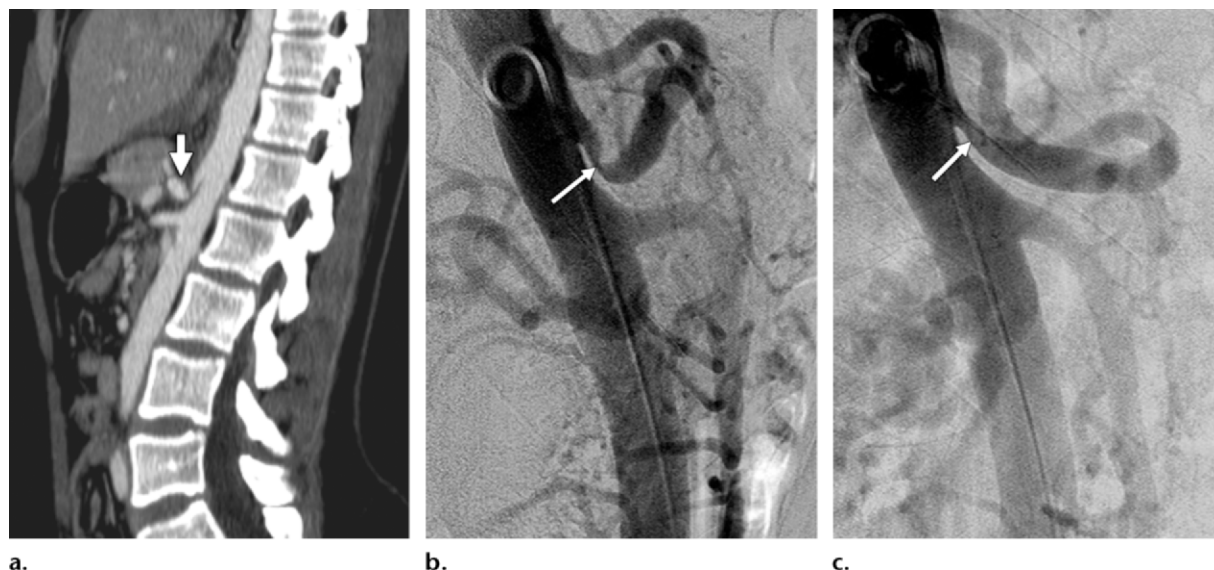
Median arcuate ligament syndrome in a 45-year-old woman with postprandial abdominal pain, intermittent nausea, and weight loss. (a) Sagittal maximum intensity projection image obtained at contrast-enhanced CT shows the proximal celiac artery with acute upward angulation, abnormal indentation over its proximal aspect, and severe poststenotic dilatation (arrow). (b) Lateral superior mesenteric arteriogram obtained at DSA at end inspiration shows a severe, persistent focal stenosis (arrow) near its origin, with poststenotic dilatation and absence of filling of the common hepatic artery. (c) Lateral superior mesenteric arteriogram obtained at DSA during simple breath holding shows a marked reduction in the severity of the stenosis (arrow) but persistent poststenotic dilatation.
